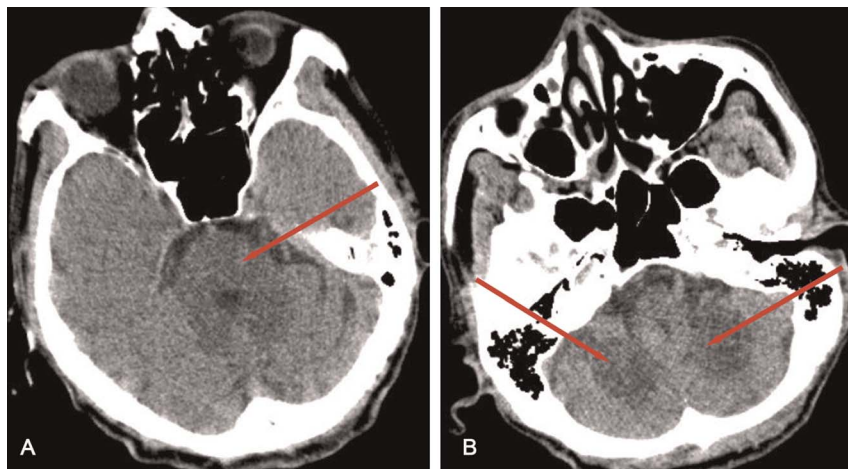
CT scan of a 67-year-old man with toxic encephalopathy due to food poisoning from money tree seeds. (A) Low-density lesions in the brainstem and the patient's dyspnea might have been attributed to the brainstem lesions. (B) Low-density lesions located in the bilateral cerebellar dentate nucleus. CT, computed tomography.
